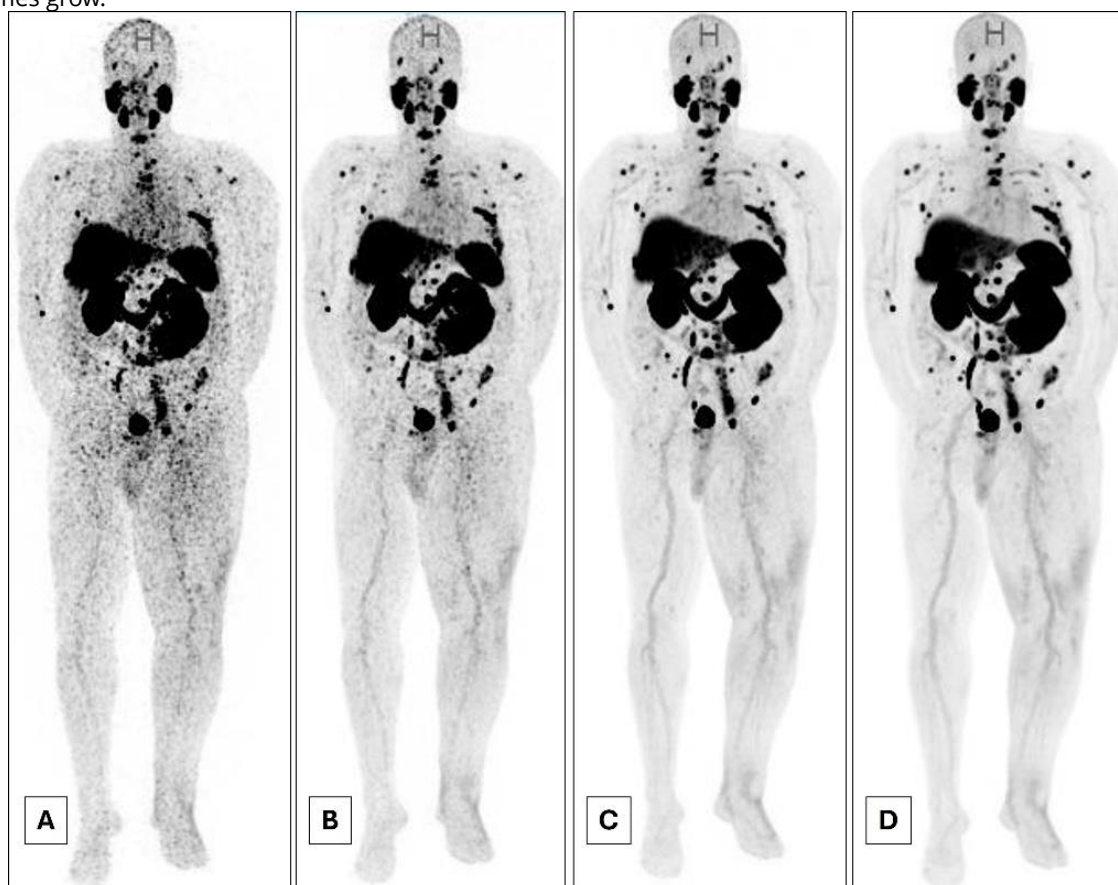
A patient with Gleason 4+3=7 prostate adenocarcinoma after androgen deprivation therapy, novel androgen-axis therapy, and docetaxel. ^{68}Ga -PSMA-11 PET/CT demonstrates widespread PSMA-positive lymph node and osseous metastases. The patient was deemed eligible for ^{177}Lu -PSMA radioligand therapy. (A-D) MIP images with varying acquisition times: (A) 10 seconds, (B) 30 seconds, (C) 2 minutes, (D) 5 minutes. Even the 30-second acquisition clearly delineates the PSMA-positive disease burden.
